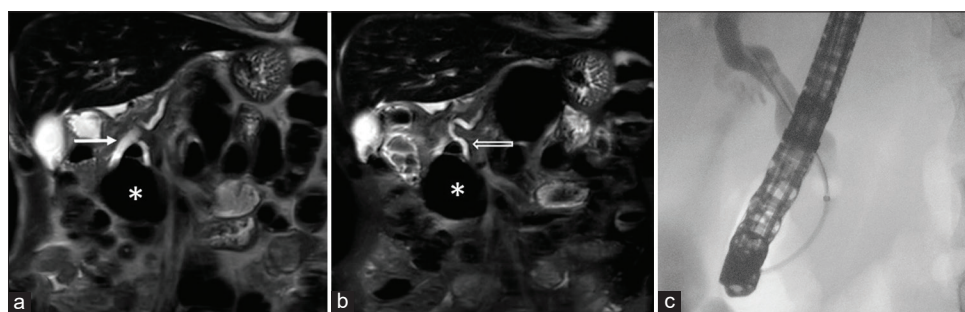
An 82-year-old man with Lemmel syndrome who presented with intermittent abdominal pain and jaundice. (a and b) Coronal T2-weighted magnetic resonance imaging of the abdomen shows an 8.3-cm perampullary diverticulum (asterisk) mechanically compressing the biliary duct with distal common bile duct (CBD) (arrow in a) and pancreatic ductal dilatation (open arrow in b). Occluded cholangiogram showed dilated CBD without filling defect (c).
